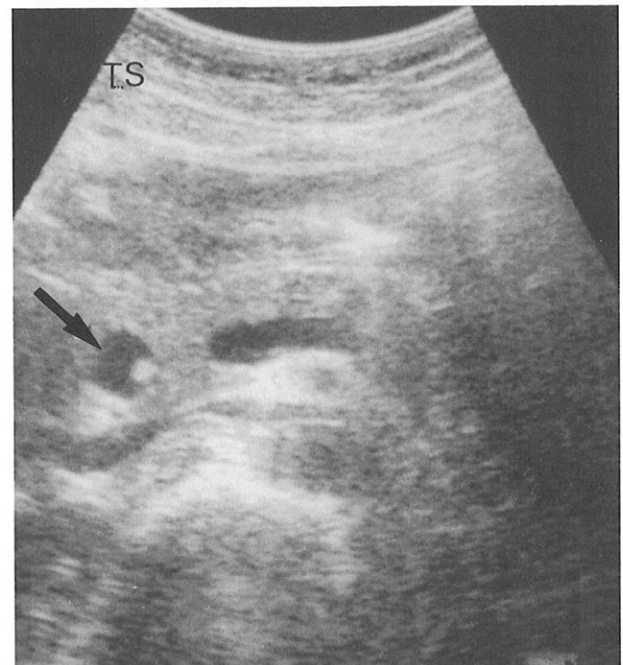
Sonogram demonstrated a calculus in a dilated intrapancreatic common bile duct (arrow).
